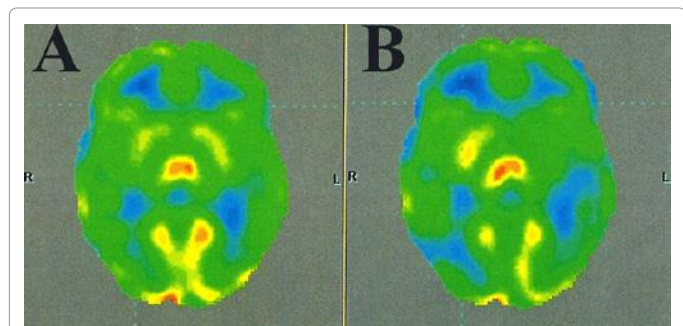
(A) PET CT scan of the patient carried out before cell therapy, (B) PET CT scan of the patient carried out after cell therapy. Comparison of PET CT scans demonstrating improvements after cell therapy i.e., the yellow areas decreased in the post intervention scan as indicated by SUV values in Table 1.
